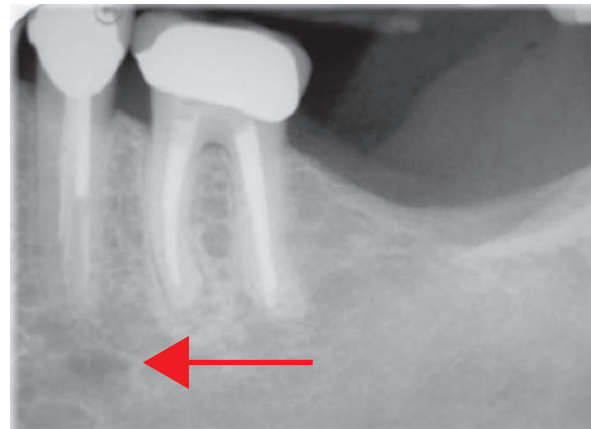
Periapical film showing the mental foramen.
